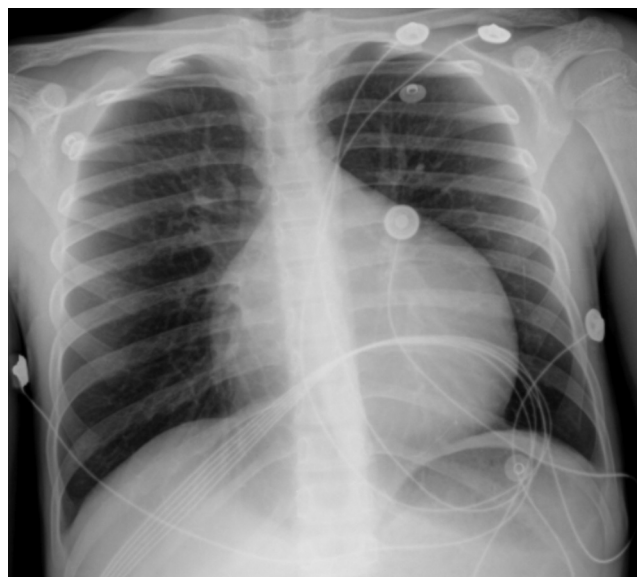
Chest X-ray showing increased cardiothoracic index and signs of pulmonary vascular congestion.
